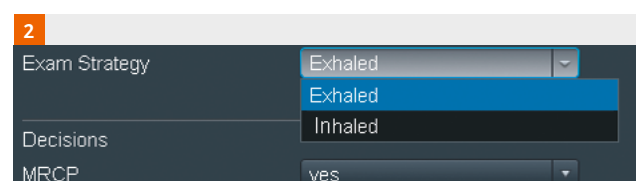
Prior to the exam, users can choose the strategy from the dialog box. In this step, they can also decide whether the individual clinical question requires a fast T2-weighted MRCP.
